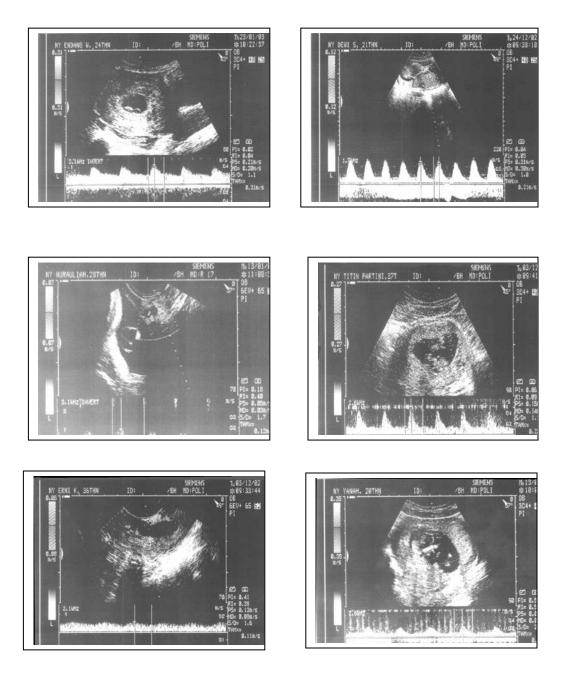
Figures of Ultrasound Doppler Velocimetry of Decidual Spiral Arteries Features in Early Pregnancy Bleeding.
